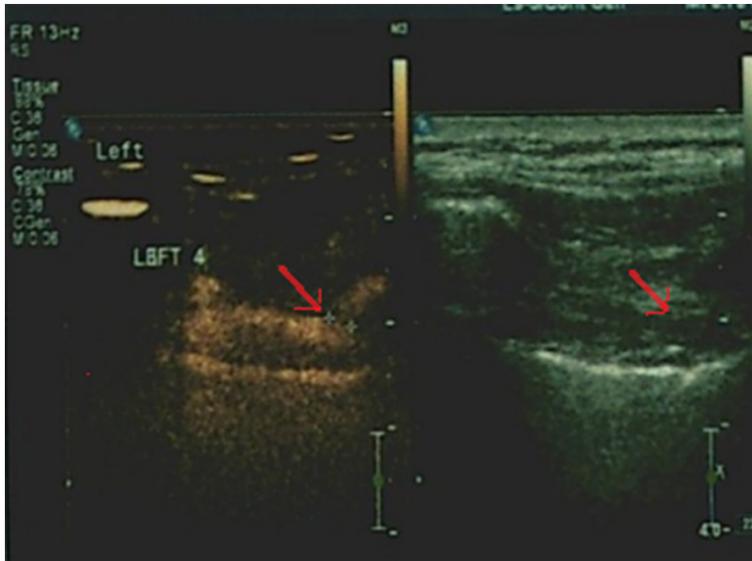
Ultrasound Images of IMAP. The track of starting point of IMAP were marked by the red arrows.
